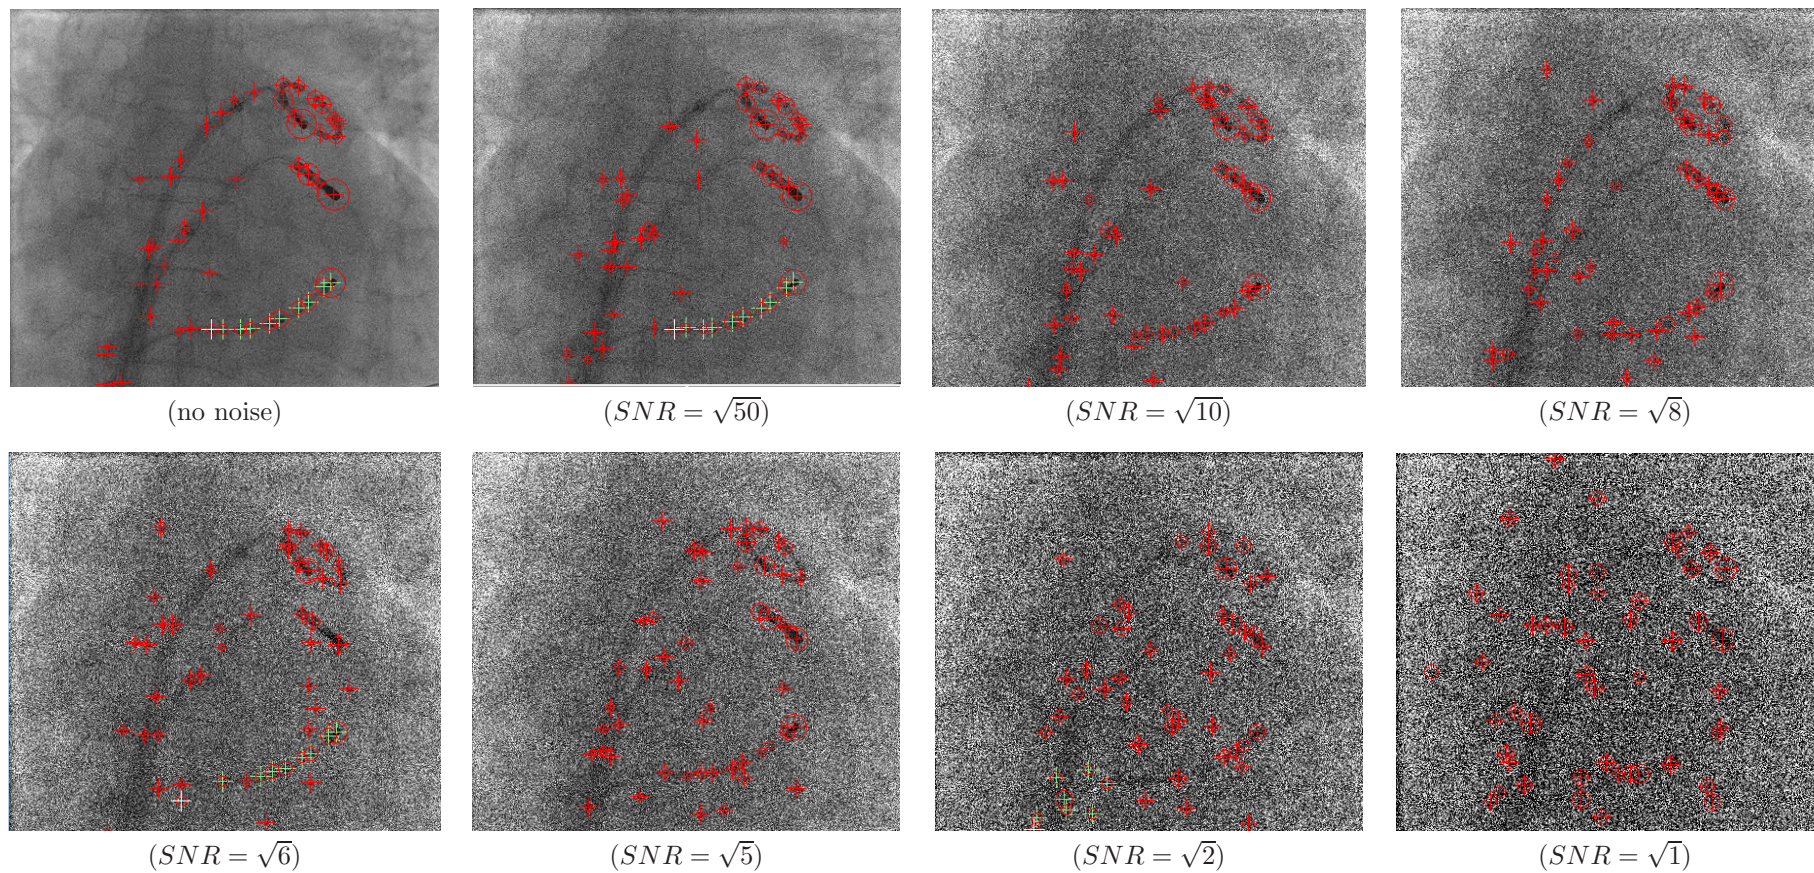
Case 1: example results from the blob detection method of an uncorrupted clinical X-ray image and the same X-ray image corrupted with different levels of Poisson noise. The CS catheter electrodes have been differentially detected, in green crosses. Red crosses are the positions of other catheter electrodes. White crosses are the positions of the proximal electrode of the CS catheter.
